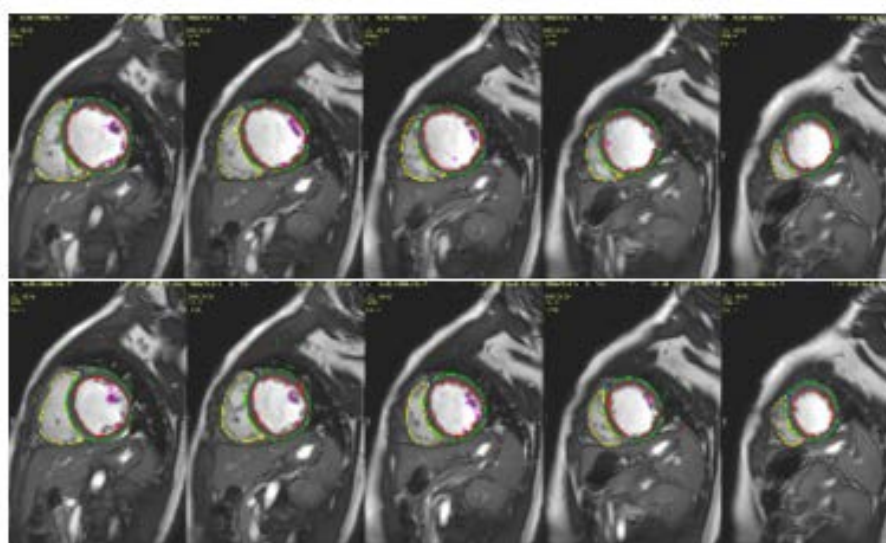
MRI during systolic and diastolic
